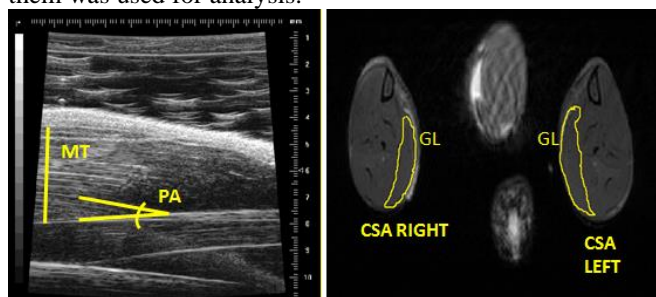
Measurements made by the software in images of UBM (left) and MRI (right), respectively.
